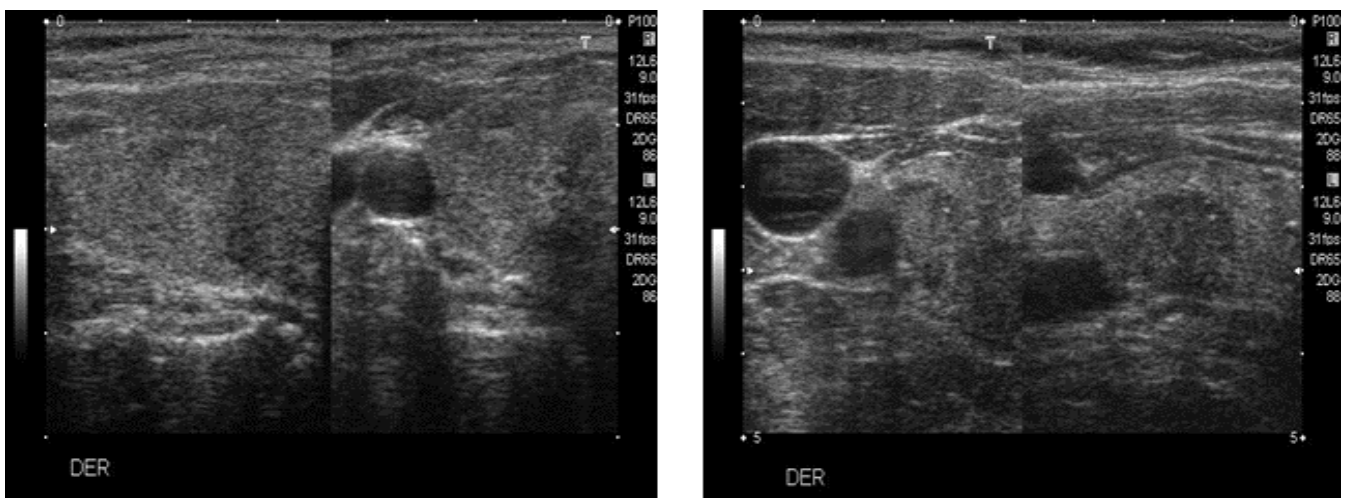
Ultrasound images for different types of thyroid carcinoma: (a) Papillary carcinoma, (b) Follicular carcinoma, (c) Medullary carcinoma, (d) Anaplastic carcinoma.
